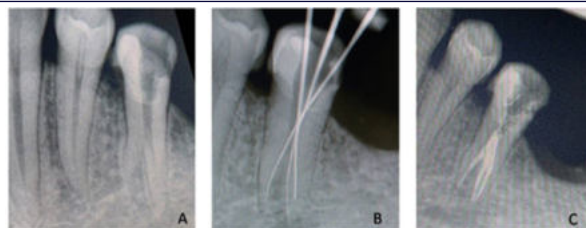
(A) Preoperative radiograph showing bifurcation of root in middle third. (B) Working length radiograph. (C) obturation completed in Buccal, mesiolingual and distolingual canals using 2%GP and sealapex sealer.
